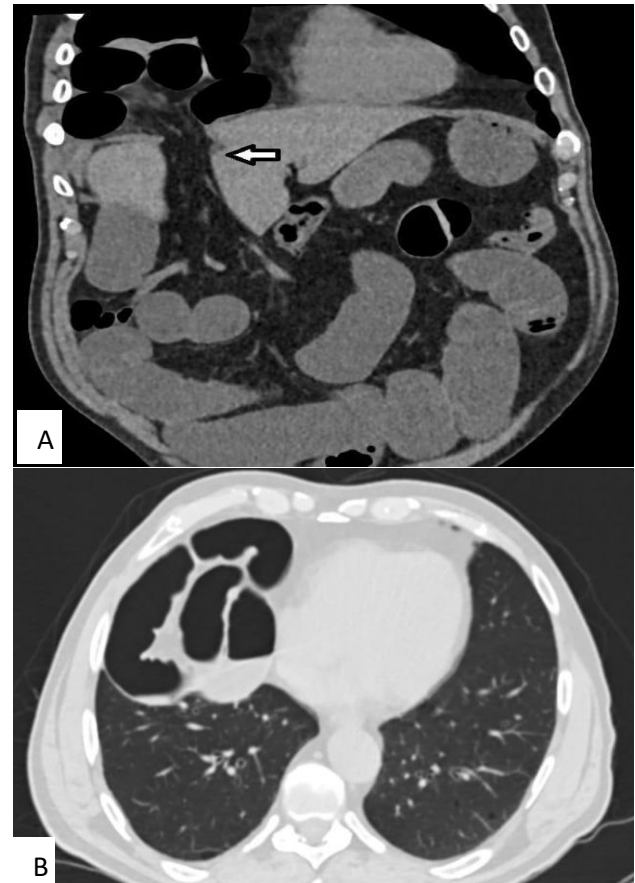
A) Coronal slice of a CT scan showing a right diaphragmatic hernia. B) Axial slice of a CT scan showing a right diaphragmatic hernia.
